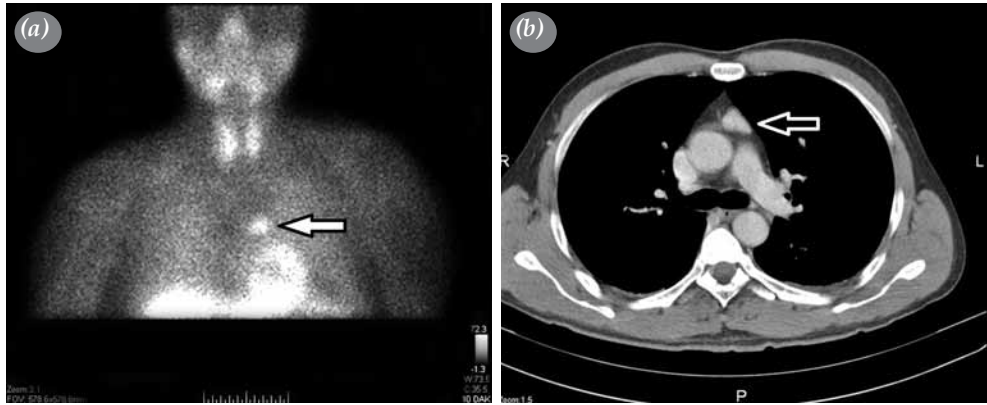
(a) Focal activity accumulation in mediastinum on preoperative parathyroid scintigraphy. (b) Preoperative thorax computed tomography revealing a concentrated soft tissue in anterior mediastinum.
